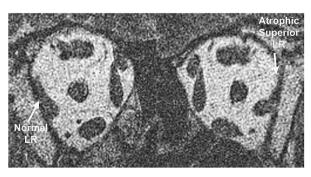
Coronal magnetic resonance images of the left and right orbits demonstrating selective atrophy of the superior compartment of the left lateral rectus (LR) muscle in compartmental abducens palsy.
